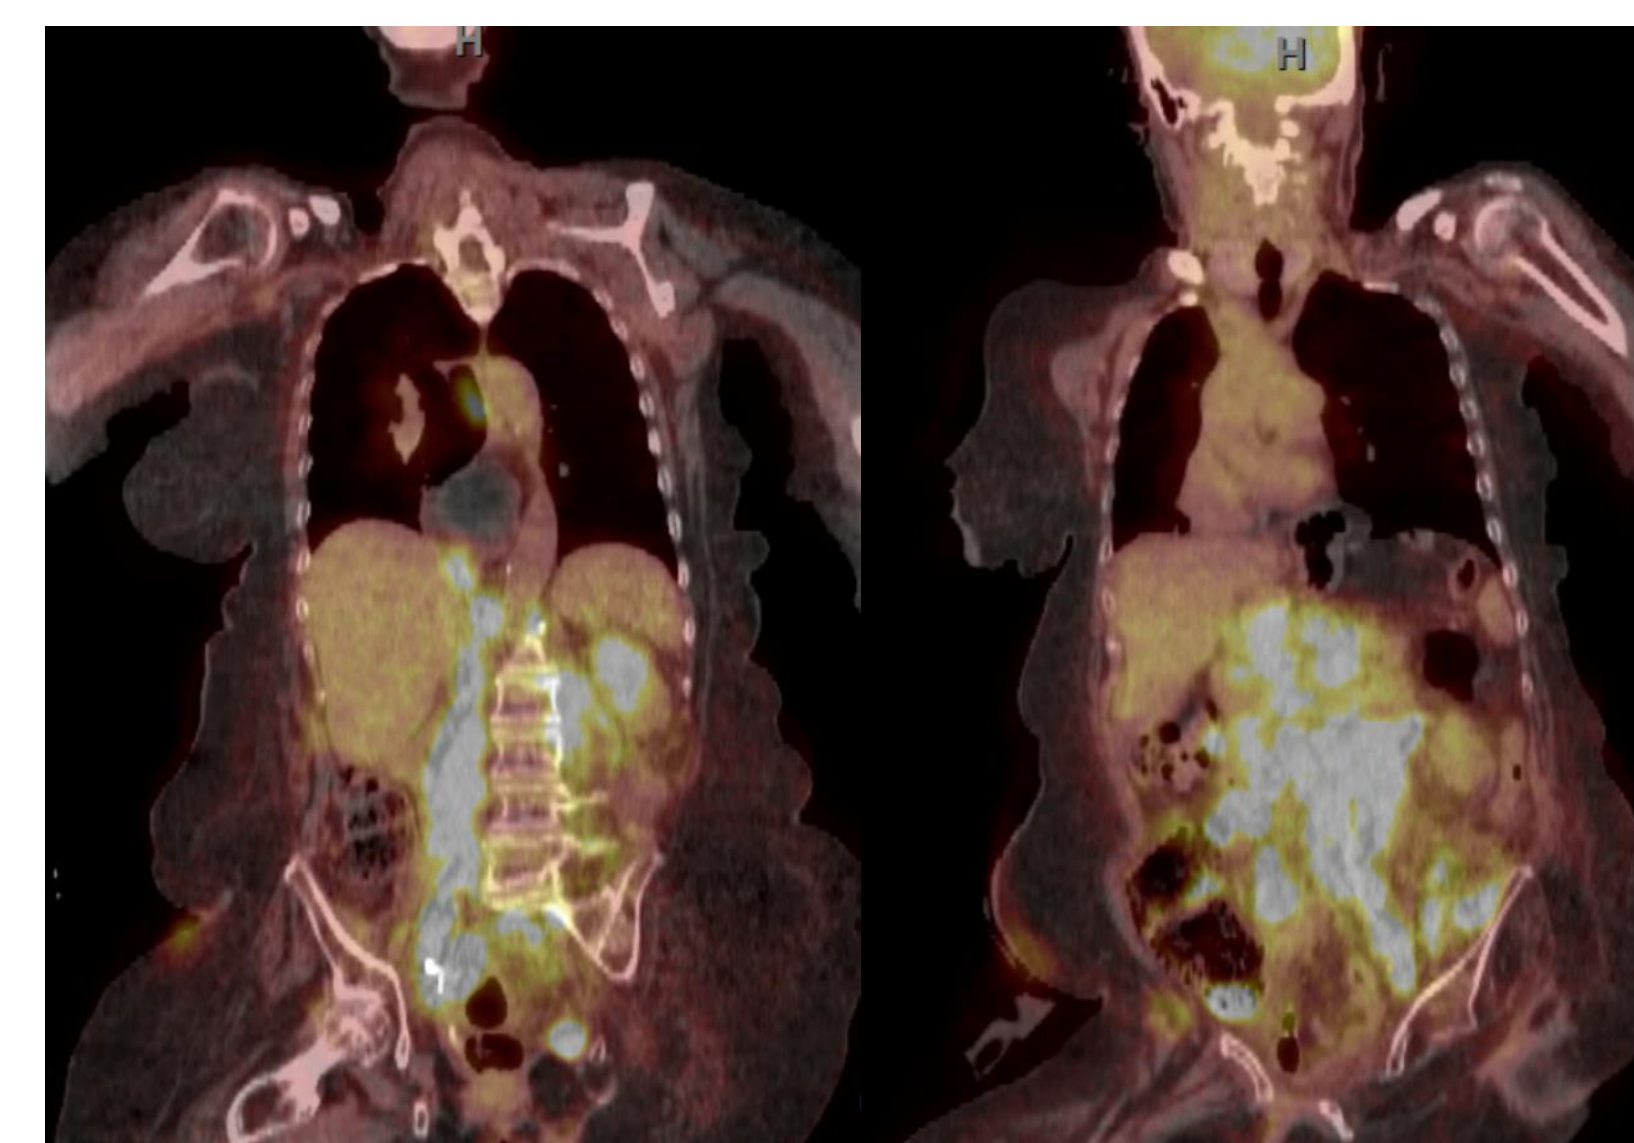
FDG PET s/p cystectomy demonstrating diffuse metastasis at 16 months
